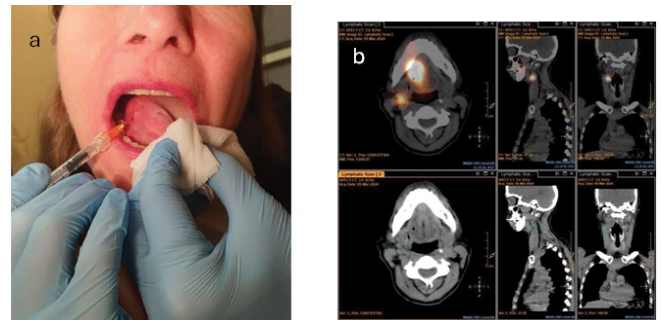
(a) Intradermal peri-lesional injection of ^{99m}Tc Tc-albumin nanocolloids; (b) Identification of the sentinel lymph node on CT/SPECT.
